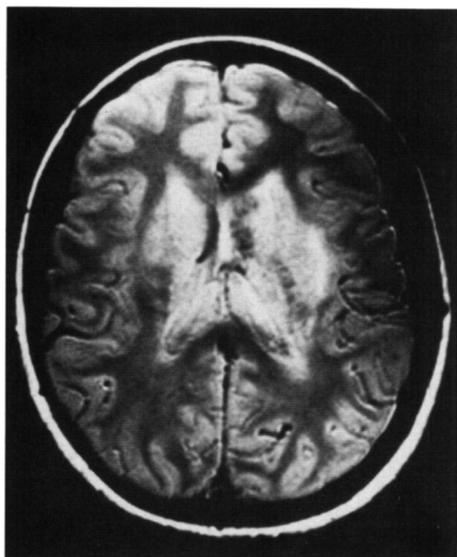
Patient 1 — T2-weighted SE MR (TR = 2100ms, TE = 60ms) three days after admission. Hypointensity in head of left caudate and genu of left internal capsule indicative of acute hemorrhage.¹ Hyperintensity in basal ganglia and thalami, internal and external capsules.
